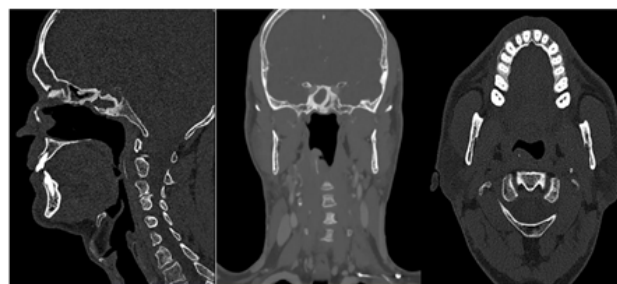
CT scans in sagittal, coronal and axial projection of the fish bone.
